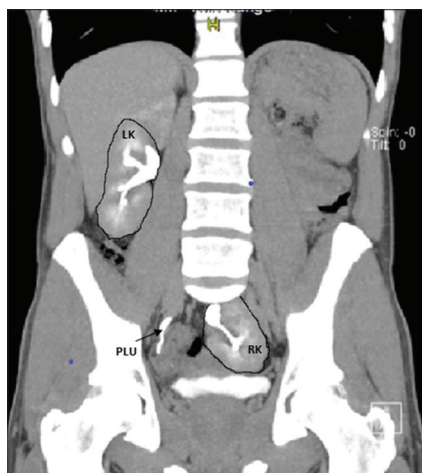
Computed tomography urogram demonstrating the right kidney, the left kidney, and the pelvic part of the right ureter
